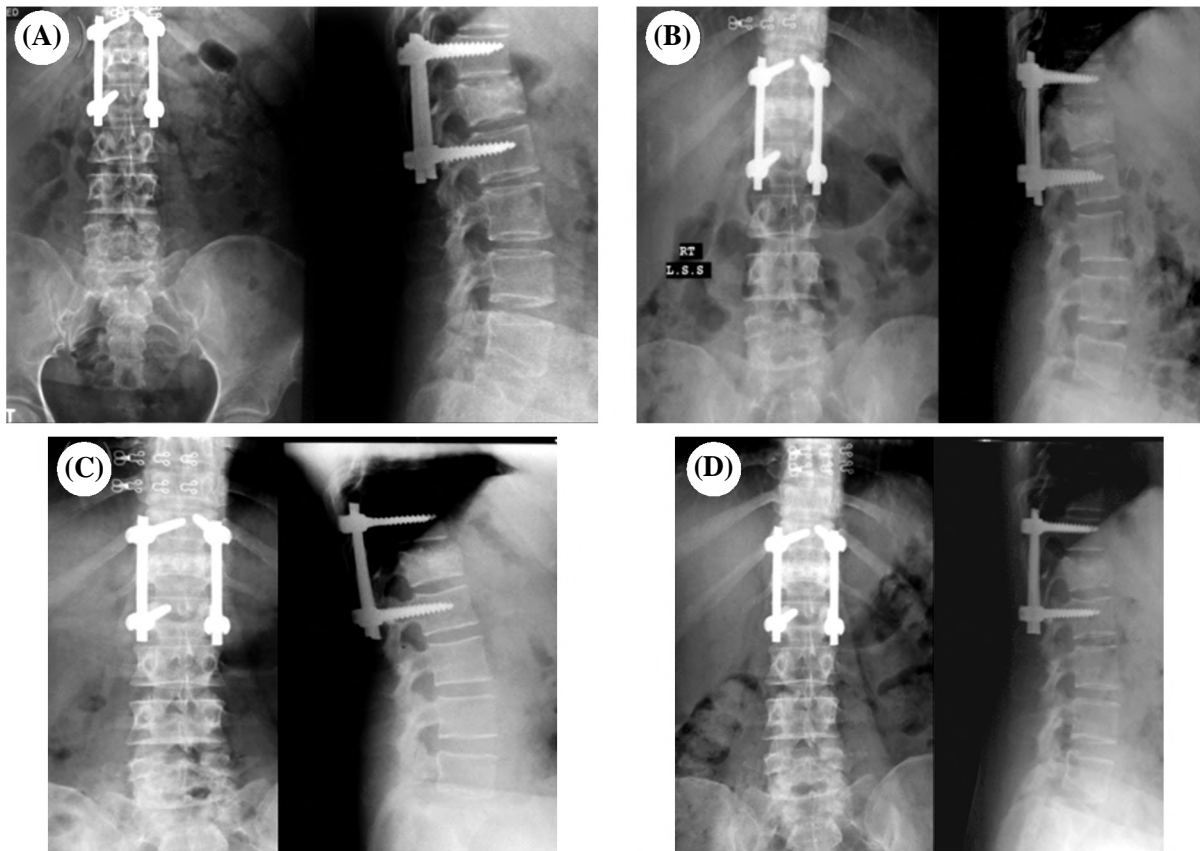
(A) Post-operative follow-up X-rays 1 month, (B) 3 months, (C) 6 months & (D) 1 year revealing maintenance of the reduction of the kyphotic angle and complete resorption of Genex. There is loss of only one degree of Cobb's angle to be at the final follow-up 4 degrees.
